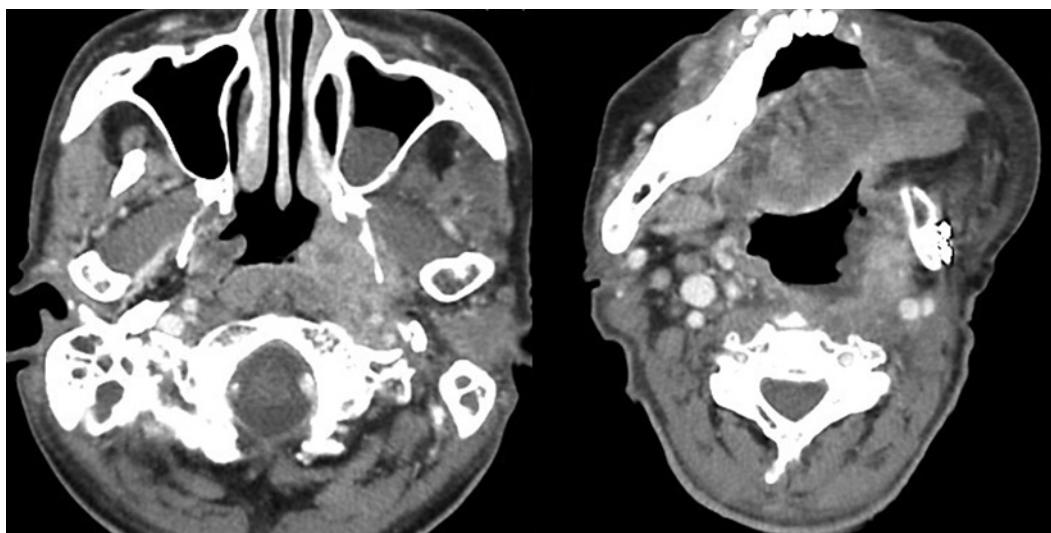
CT images of disease progression after HN-PIT.
